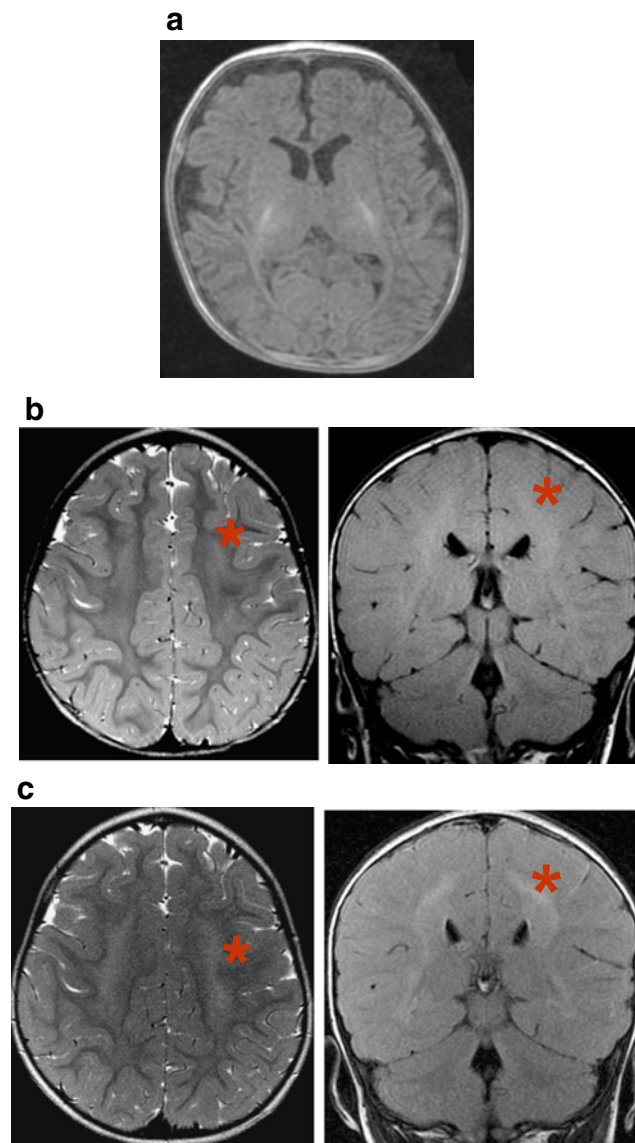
Brain magnetic resonance imaging (MRI) on enzyme replacement therapy (ERT) on follow-up showing white matter changes appearing at the age of 20 months compared with MRI at diagnosis. At the age of diagnosis (a), T-1 axial with normal age-appropriate images showing normal myelination. At the age of 20 months (b): on the *left*, axial T-2 image; on the *right*, coronal fast low-angle inversion recovery (FLAIR) image. Changes in white matter, sparing U fibers (*); MRI at 32 months (c): on the *left*, axial T-2 image; on the *right*, coronal FLAIR image. In comparison with b, increased white matter signal intensity (*)
